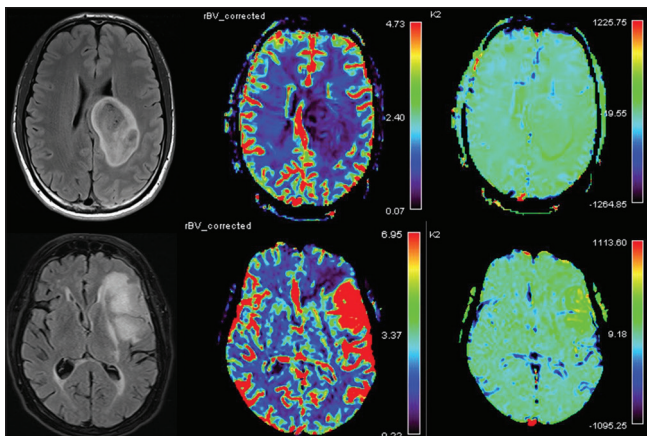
Relative cerebral blood volume differences in a LGG versus a high-grade glioma. Axial FLAIR (left), relative cerebral blood volume (middle) and leakage (K2) maps of two patients with gliomas. Upper row: WHO II isocitrate dehydrogenase mutated glioma with decreased relative cerebral blood volume without leakage. Lower row: WHO IV isocitrate dehydrogenase mutated tumor with increased relative cerebral blood volume and increased leakage
